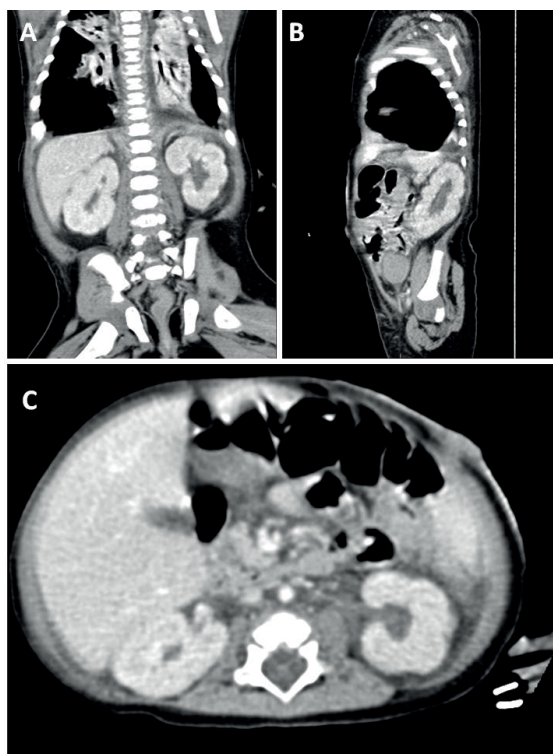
Computed tomography after drainage of kidney abscesses and specific antifungal therapy, showing evidence of resolution of the findings described.
